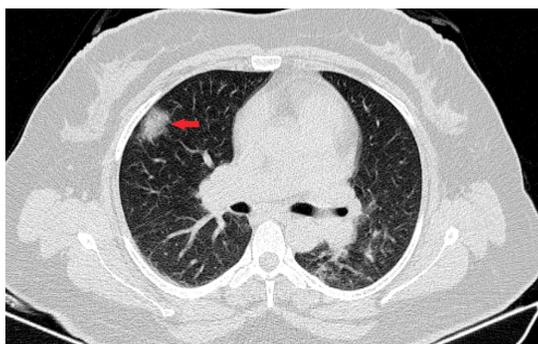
Axial chest CT demonstrated a nodule with halo sign in the right middle lobe (red arrow).
